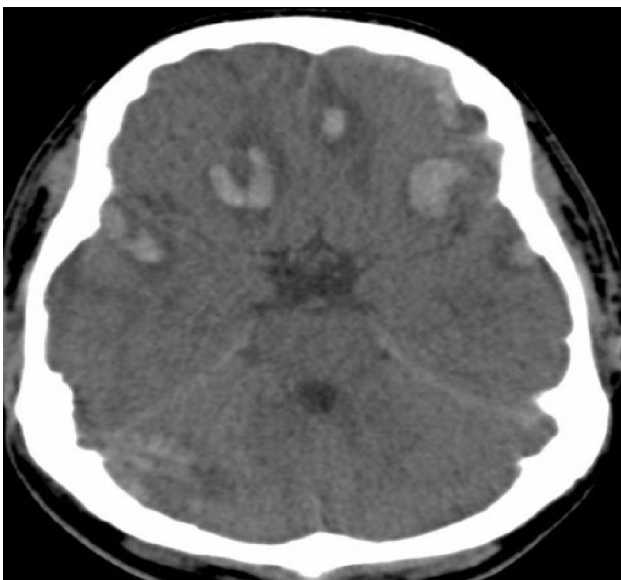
CT scan Axial Brain Image: Multiple hemorrhagic contusions are seen at gray white matter interface of bilateral frontal and temporal regions with perifocal edema and mild effacement of cortical sulci. Contusion hematoma is also seen in cerebellum on right side.
